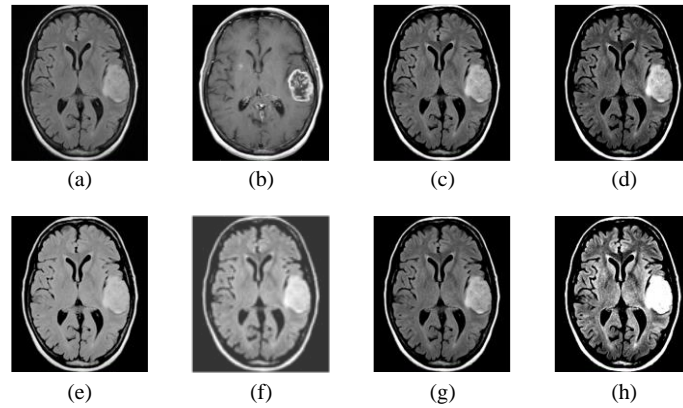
represents the MRI-CT fusion a) MRI image b) CT- image c) AD-Net d) DL-Net e) AutoNet f) CrossNet g) Improved-U-Net h) Our method.
